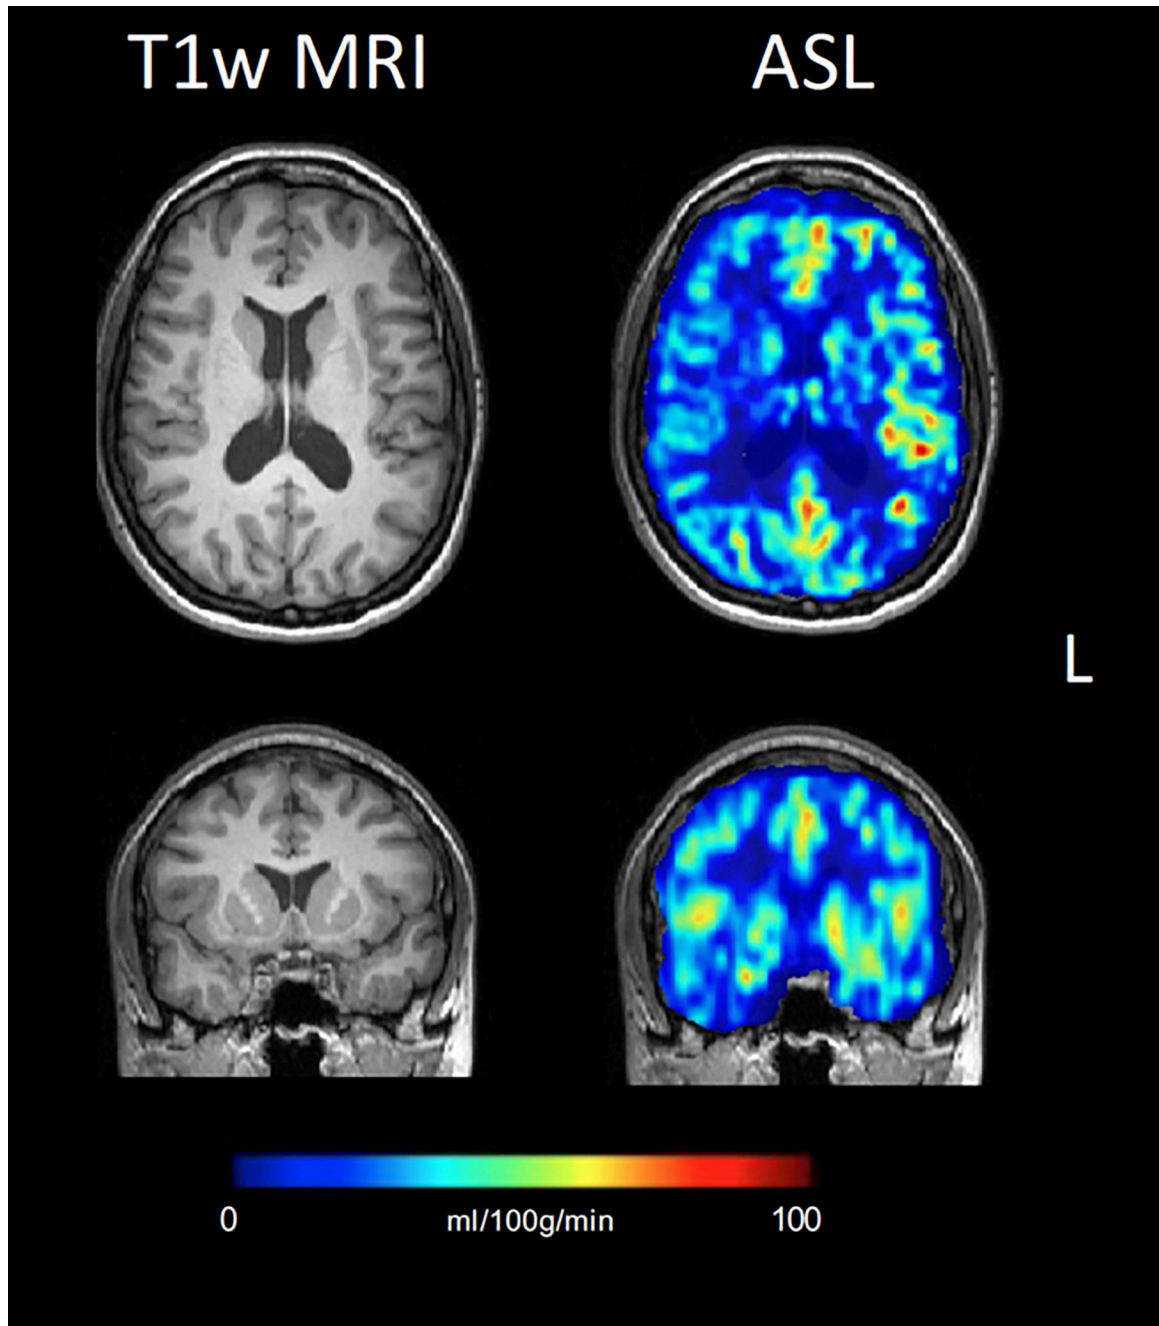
Interictal ASL CBF map showing right fronto-temporal hypoperfusion in a patient without any morphological-structural alterations identified on structural MRI, but with clinical and EEG localization to the right fronto-temporal lobe and right temporal hypometabolism on interictal PET (not shown).
